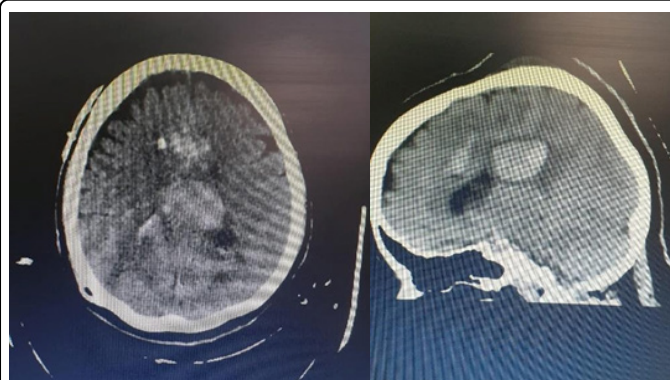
CT brain plain showed intraventricular hemorrhage.
